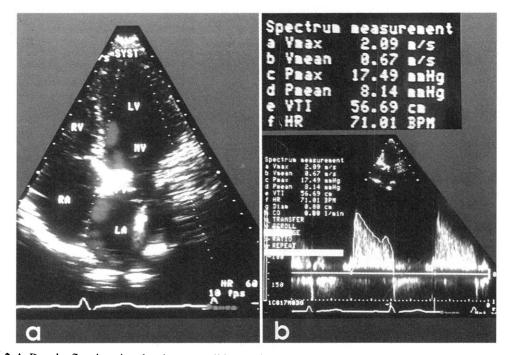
A, Doppler flow imaging showing very mild regurgitation of the autograft and B, continuous wave Doppler, Mean diastolic gradient = 8 mm Hg. *Vmax*, Maximum velocity; *Vmean*, mean velocity; *Pmax*, maximum pressure; *Pmean*, mean pressure; *VTI*, velocity time interval. For other abbreviations see Fig 1.
